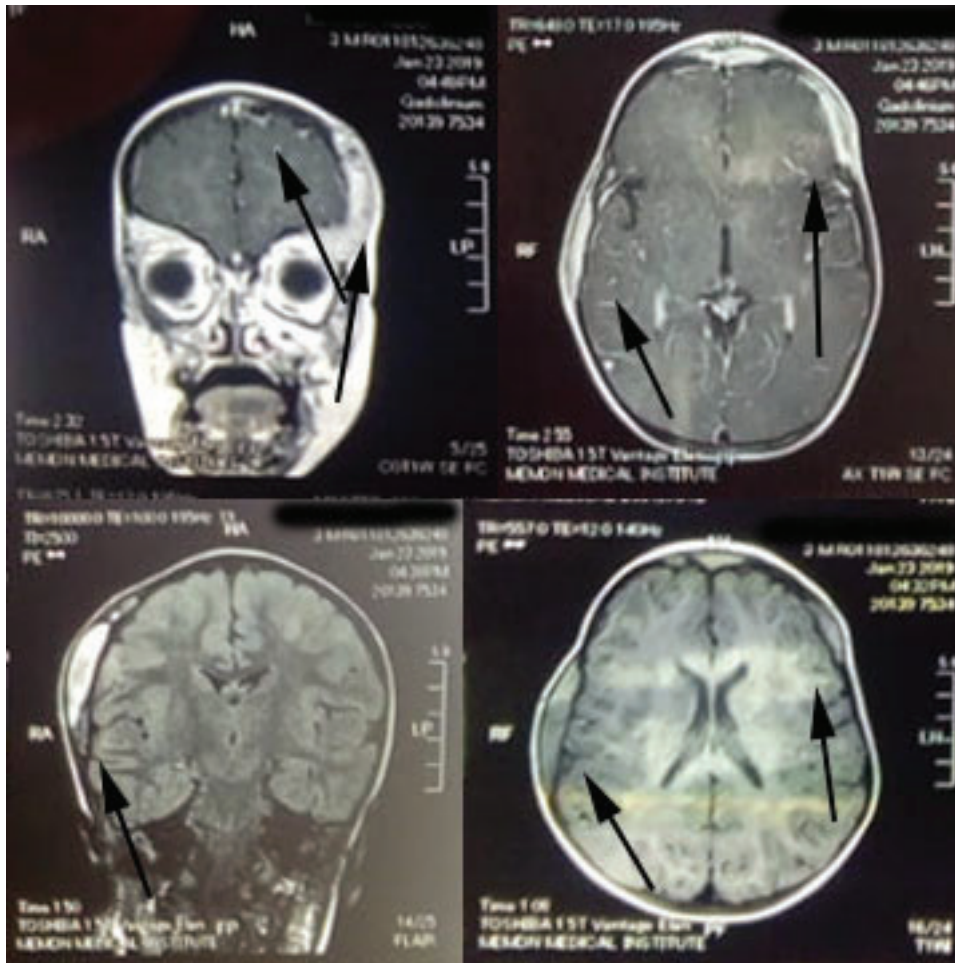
MRI Brain an expansile mass in right parietal bone and heterogeneous lesion left frontal bone.
